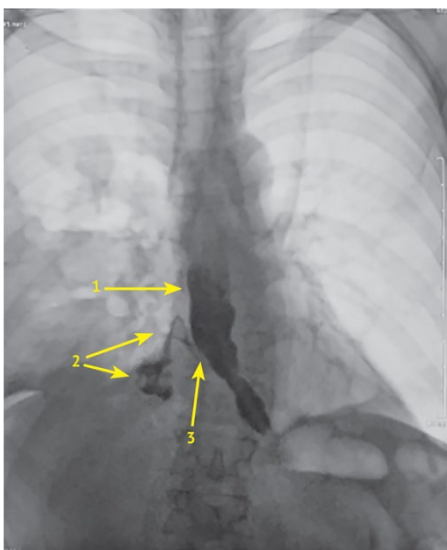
X-ray scan of the esophagus with water-soluble contrast, front view. 1 — lower thoracic esophagus; 2 — contrast flowed beyond the contrast esophagus into the mediastinum and the right pleural cavity; 3 — esophageal-pleural fistula
